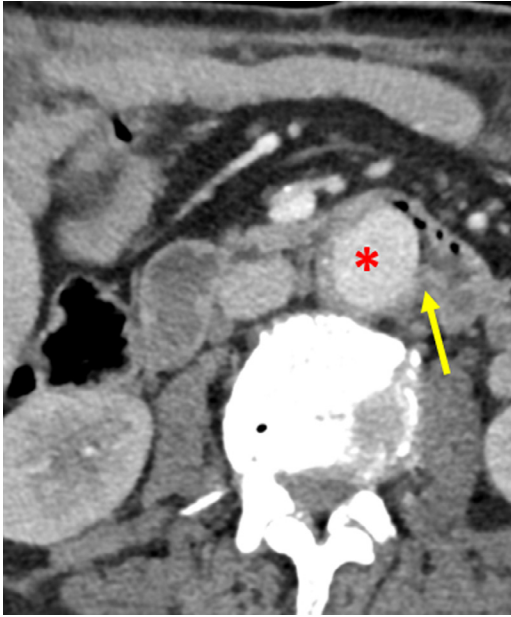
CT-scan with intravenous injection of contrast medium showing the migration of the aortic prosthesis (asterisk) into the duodenum with breach into the posterior duodenal wall (arrow).
